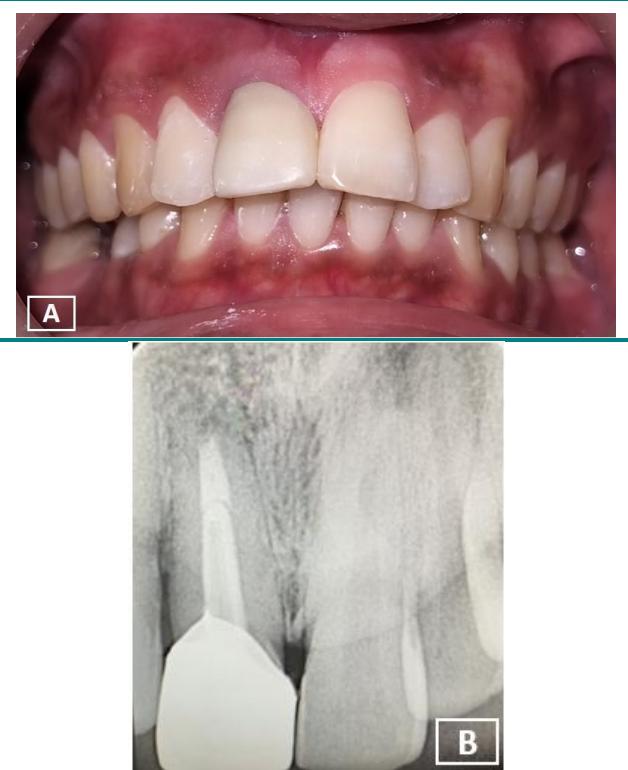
A. Postoperative clinical photograph at 6 months follow-up, and B. Intraoperative periapical radiograph of tooth 11 at 6 months follow-up.
